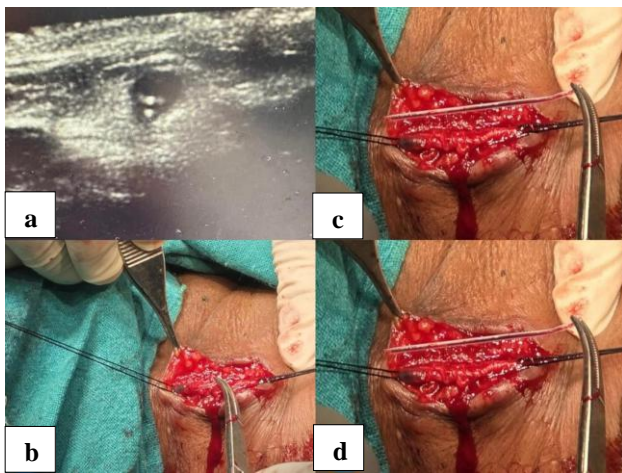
(a) Ultrasound showing hyper enhanced intraluminal foreign body present in the left EJV, (b) showing intraluminal cannula removal, and (c) and (d) showing after removal of IV cannula.
